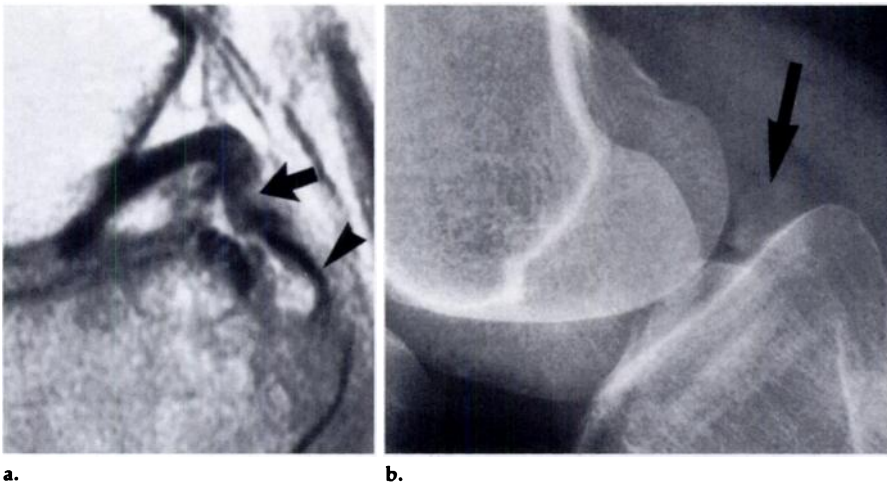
Images of a 38-year-old man whose knee struck a buoy during a waterskiing accident. He had no evidence of posterior instability at initial clinical examination but demonstrated a posterior drawer sign when examined under general anesthesia. (a) T1-weighted sagittal MR image shows redundancy of the PCL (arrow), which is attached to an avulsed fragment of bone (arrowhead). (b) Radiograph shows only the avulsed osseous fragment (arrow). Findings were confirmed at the time of surgical repair of the avulsion.
